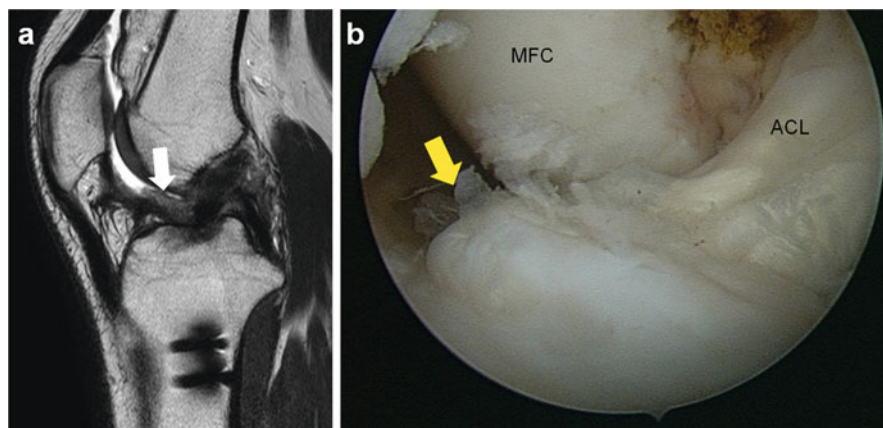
A case that required additional synovectomy because of the prolonged loss of extension after anatomic double-bundle ACL reconstruction with notchplasty. (a) MRI (*sagittal view*) taken 3 months after surgery showed fibrosis of the infrapatellar fat pad (*white arrow*) adhered to the reconstructed ACL. (b) Arthroscopic view from the anterolateral portal. Fibrosis of the infrapatellar fat pad (*yellow arrow*) adhered to the reconstructed ACL
